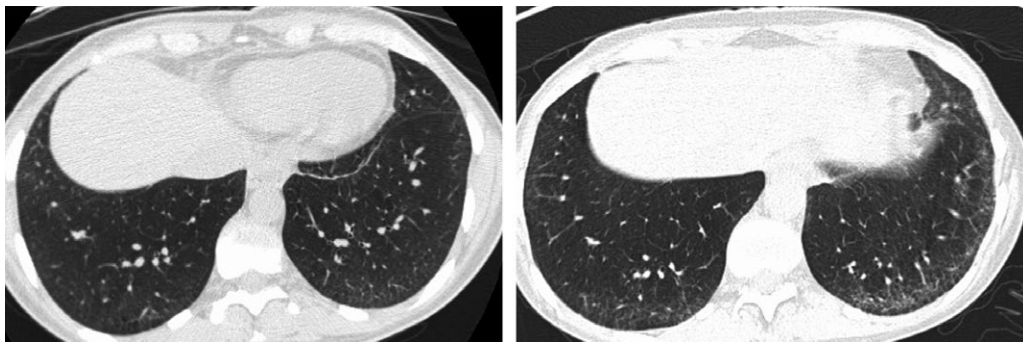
Progression of interstitial lung abnormalities in a patient with systemic sclerosis, as demonstrated by computed tomography. The image on the right was obtained 3 years after the image on the left.
